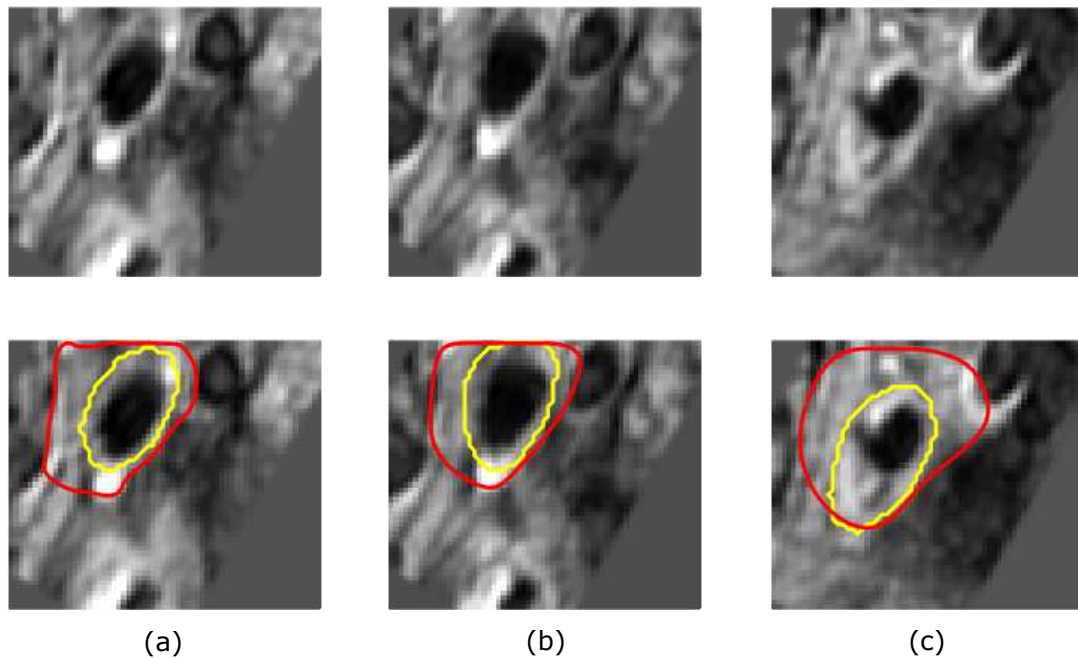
Examples of carotid artery boundaries segmented by the proposed approach in PDW MR images with indistinguishable boundaries: The first row shows the original PDW MR images and the second row presents the segmented carotid artery boundaries (in red) along with the corresponding manual delineations (in yellow). (The differences found between the areas of the segmented and manually delineated carotid artery boundaries shown in images (a-c) were 399 pixels, 297 pixels and 582 pixels, respectively.)
